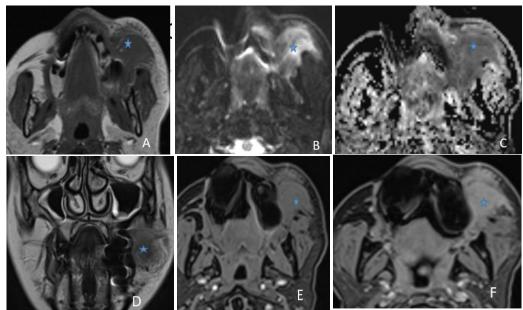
Axial T1-weighted (A) with diffusion-weighted sequence (B) and apparent diffusion coefficient (ADC) map (C), coronal T2-weighted (D), and Dixon water images before and after contrast enhancement. Poorly defined left jugal lesion (asterix) displayed T1 and T2 iso signal, with diffusion hypersignal and intense enhancement and ADC restriction after injection of Gadolinium. The lesion infiltrates the homolateral masseter muscle the subcutaneous fatty plane and also mads contact with the ascending ramus.
